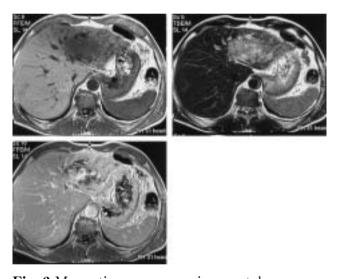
Magnetic resonance image taken upon admission to the university hospital. The tumor appeared as a low-intensity mass on the T1-weighted image (A) and as a high-intensity mass on the T2-weighted image (B). The tumor was enhanced by contrast medium (C).
